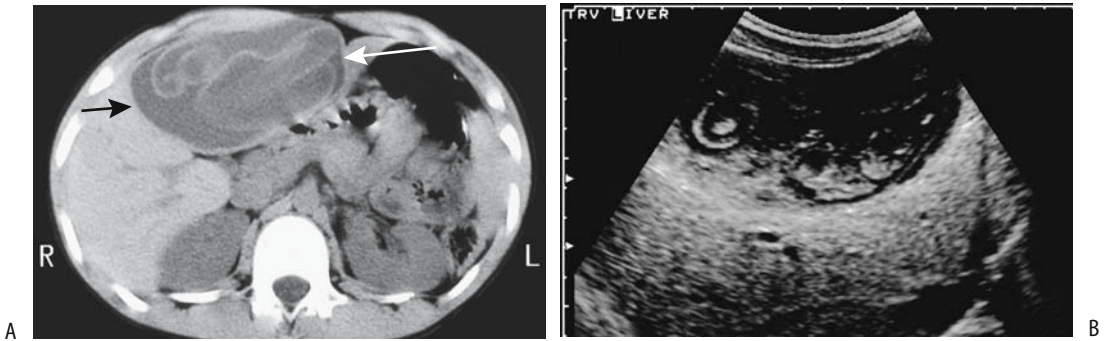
Hydatid liver cyst in a 12-year-old. A: CT identifies a large cystic structure replacing most of the left lobe (arrows). A detached inner layer is seen floating in the cyst lumen. B: Ultrasonography (US) reveals an irregular cyst containing solid content (endocyst). (Courtesy of Luann Teschmacher, M.D., University of Rochester.)
